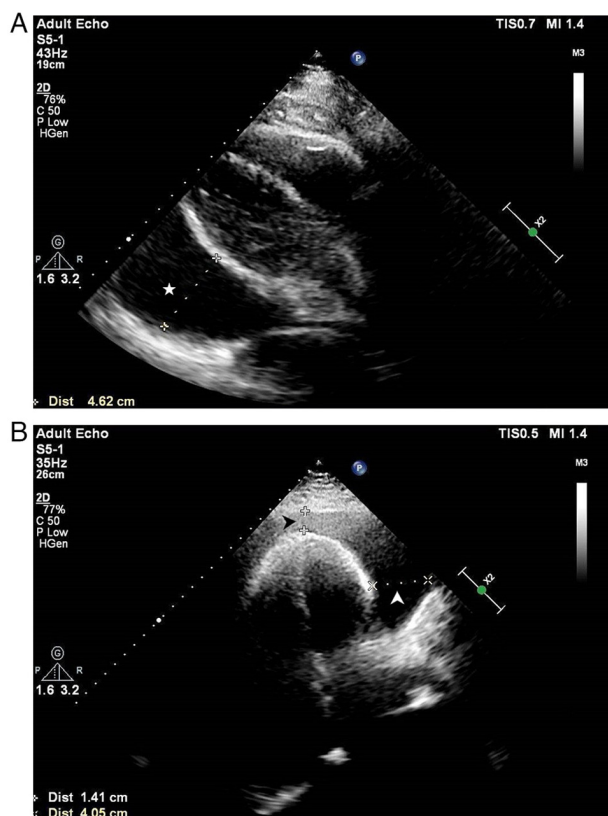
Echocardiography in November 2021. A large fluid-dark area was observed in the pericardial cavity. (A) The depth of effusion was 46 mm posterior to the left ventricle (white star), (B) 41 mm lateral to the left ventricle (white arrow) and 14 mm apical to the heart (black arrow).
